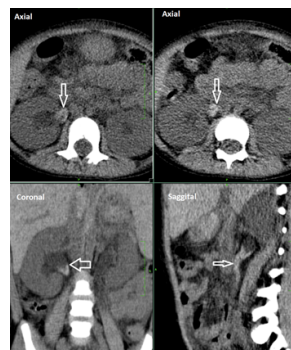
CT images showing suburothelial curvilinear hyperdensity in right renal pelvis causing right proximal hydronephrosis (Arrows).
